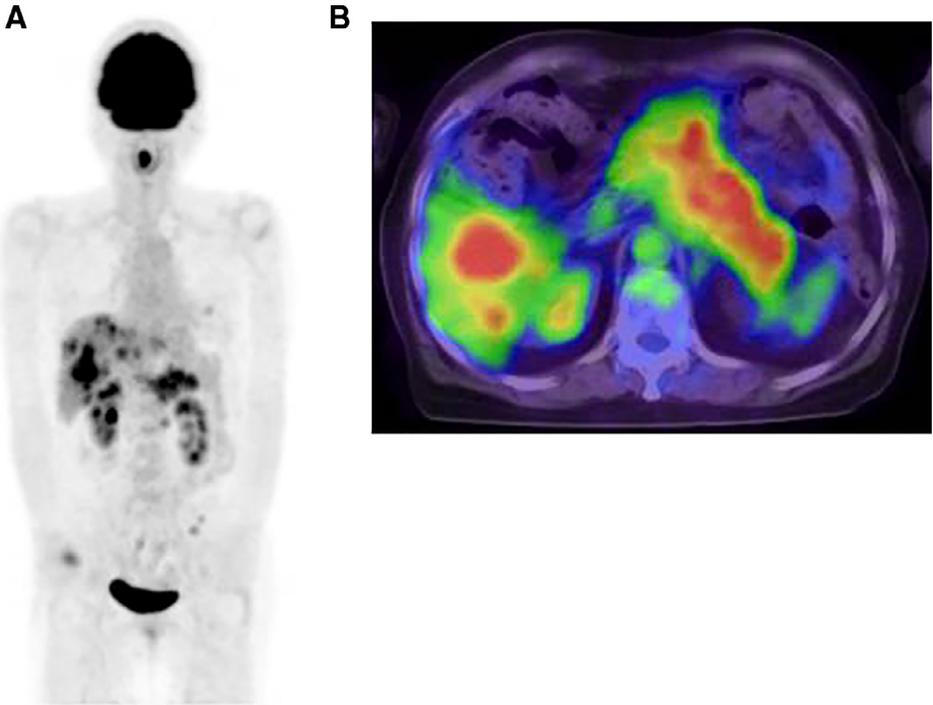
(A) Three-dimensional maximum intensity projection of PET/CT imaging.
